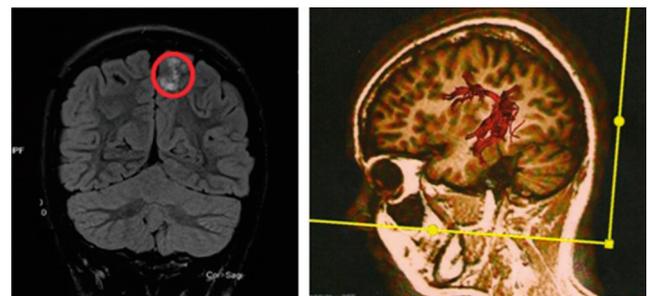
a) MR-3T with marked area of the lesion and b) functional MRI with a location of *Fasciculus arcuatus*
